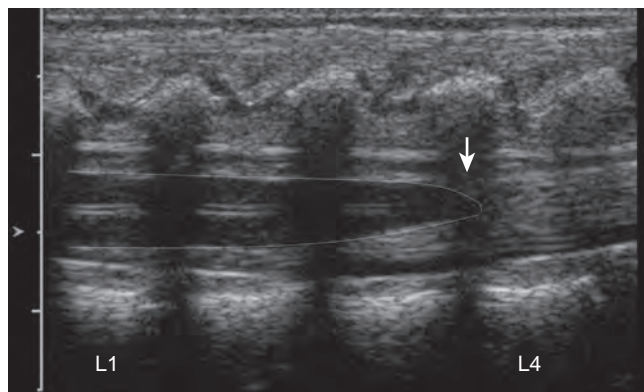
Spine ultrasound performed in a child with a sacral dimple, demonstrating a low-lying conus (at L4 level) (*arrow*). Note shadow by bony component of vertebral bodies.
